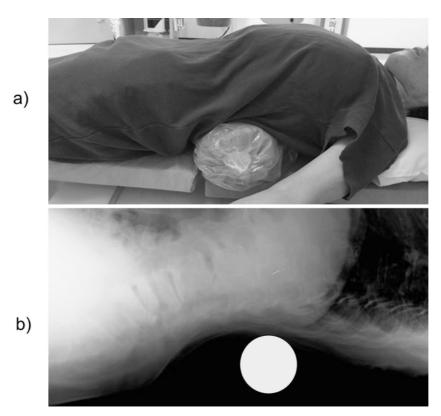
Rollback imaging.a) A firm pillow measuring 20 cm in diameter is placed beneath the fractured vertebral body, and lateral radiographs are taken 5 min later.b) Lateral radiograph using rollback imaging.
